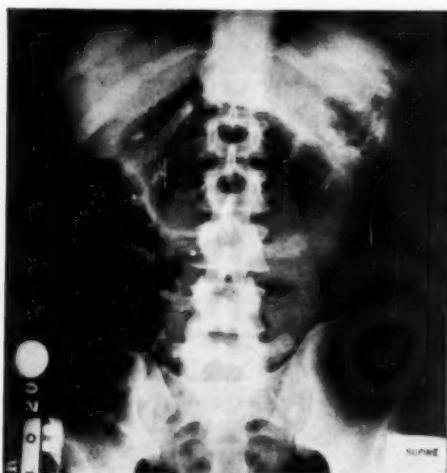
Volvulus of transverse colon. Plain film in supine position.
